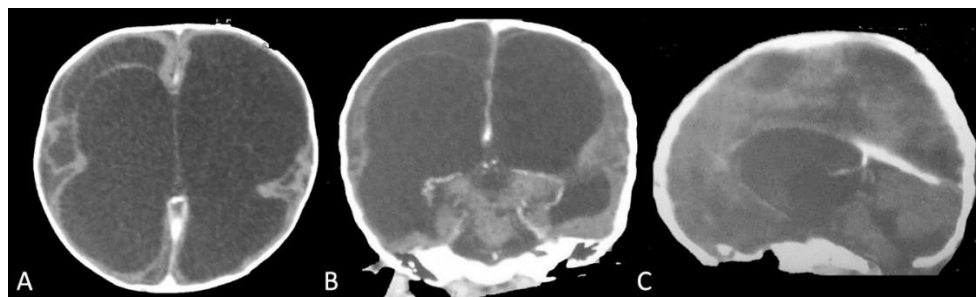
Preoperative CT-scan revealed craniostenosis on axial (A), coronal (B) and sagittal view (C) with severe hydrocephalus.
